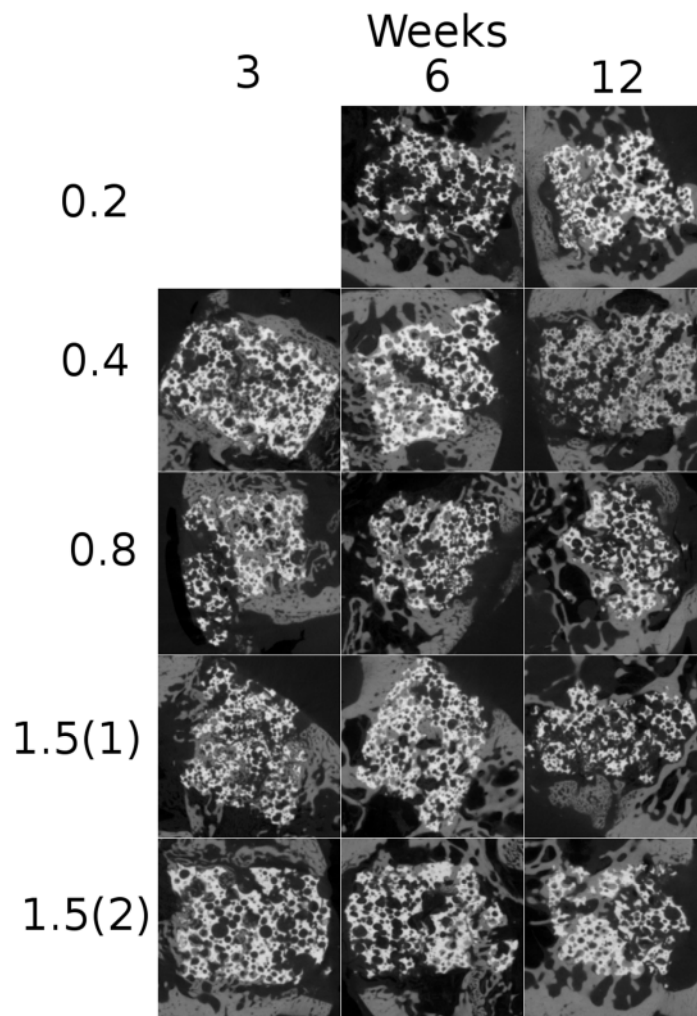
CT midway slices of all SA orthotopic samples at all time points for the possible samples.
